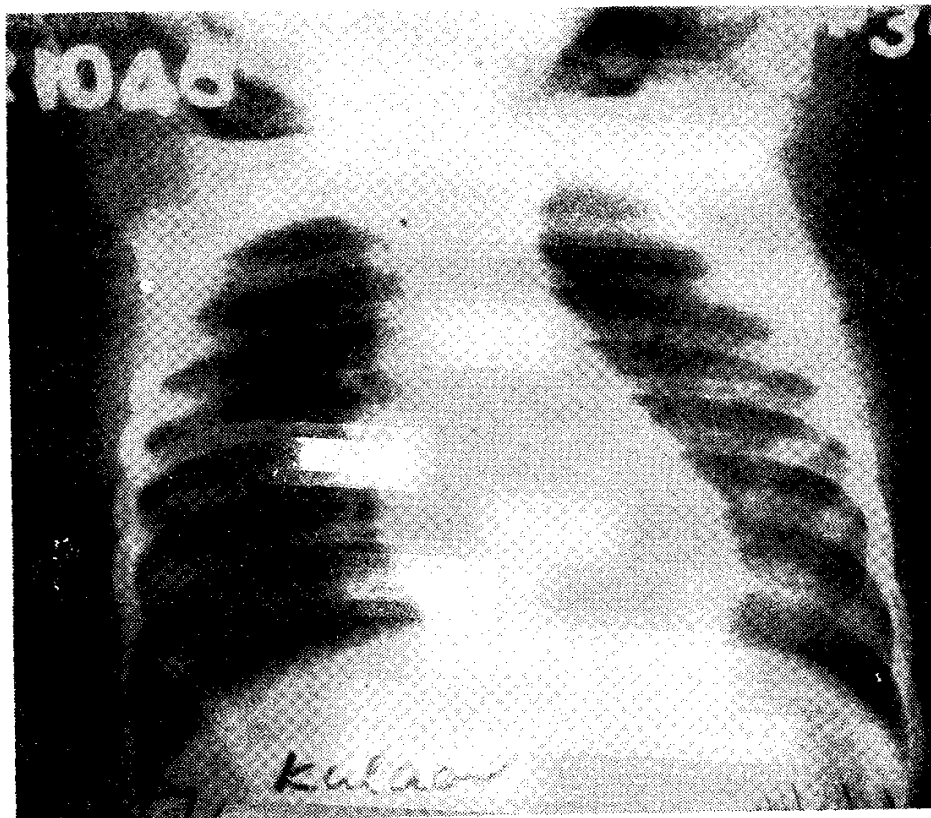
X-ray chest AP view showing bilateral subcutaneous emphysema of neck and pneumomediastinum.
